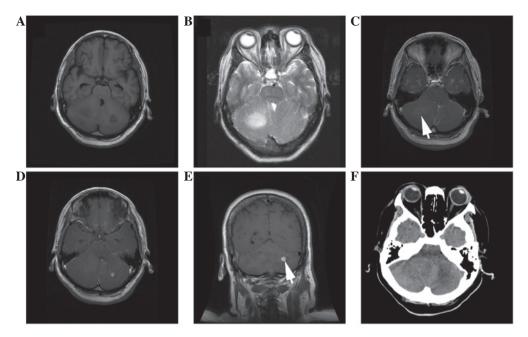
Anaplastic ependymoma of the bilateral cerebellar hemispheres in a 58-year-old female. (A) Axial T1WI showing solid masses with slight hypointensity in the bilateral cerebellar hemispheres. (B) Axial T2WI showing homogeneous hyperintense with mild peritumoral edema. (C-E) Post-contrast axial and coronal T1WI displaying (C) mild enhancement (arrow), (D) nodular enhancement and (E) nodular enhancement. (F) Computed tomography image showing low density in the cerebellum. WI, weighted imaging.
